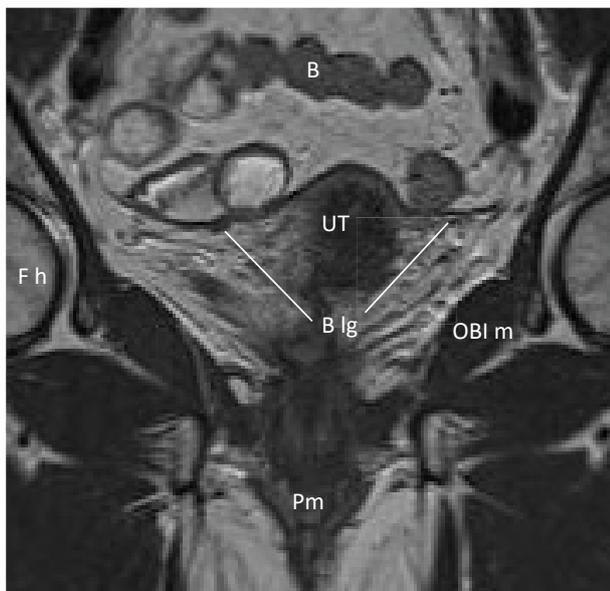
Coronal T2- weighted MR image obtained at the level of femoral heads: after covering the uterus, the double layers of peritoneum come into contact one to another on the sides to produce the 3-mm thick linear appearance of the broad ligament. Note the wing-like feature of the ligament connecting the uterus to the pelvic side walls. B= bowel; UT= uterus; OBI m = obturator internus muscle; Pm= perineal membrane; B lg= broad ligament; Fh= femoral head.
